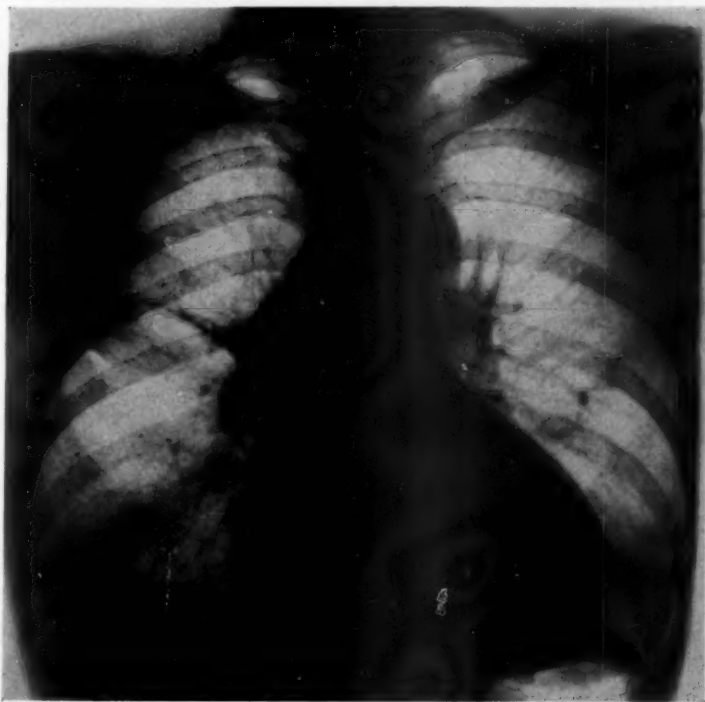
Radiograph of the thorax. Heart increased in width. Bulging ascending aorta. Streak-shaped density in right lung field.
